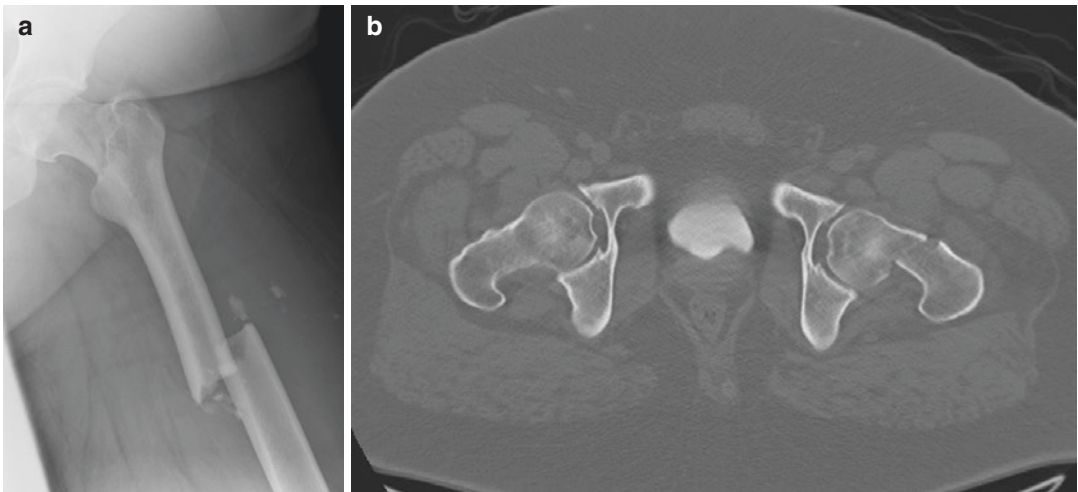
(a) An AP radiograph of the left proximal femur demonstrates a completely displaced transverse diaphyseal femur fracture. The femoral neck is difficult to visualize. There is a radiolucency along the femoral neck. (b) Thin sliced axial CT of the femoral neck confirms left femoral neck fracture
